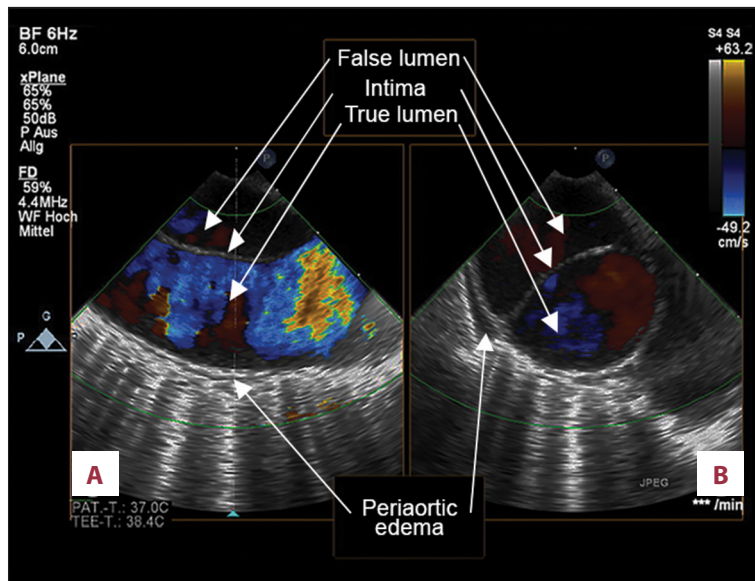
Transesophageal echocardiography: signs of aortic dissection in the proximal segment of the descending aorta in sagittal (A) and transversal view (B).
